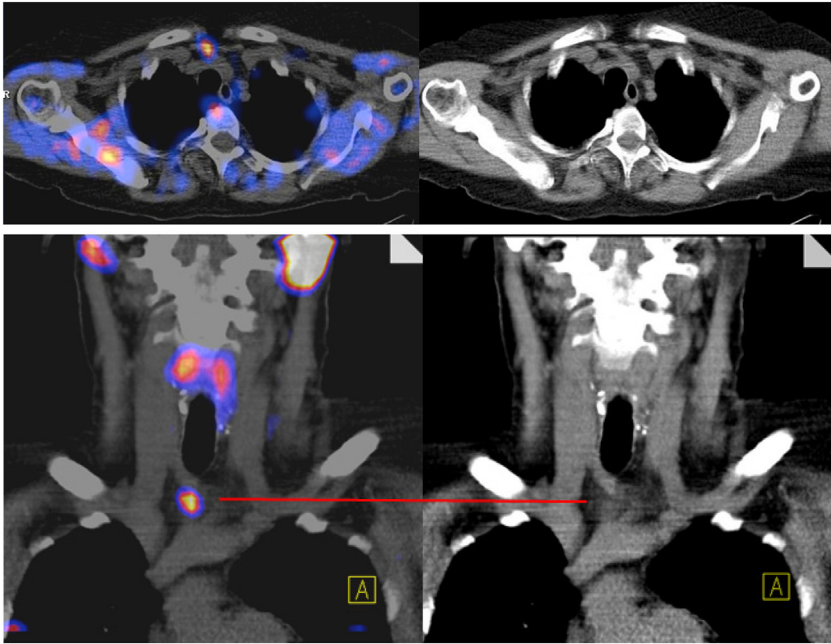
Neuroendocrine tumor of the neck in the transverse (above) and coronary plane. Normal CT on the right, SPECT on the left. The active lump is clearly visible on SPECT (red bar, gray bar in print, marks the corresponding site). *All: Courtesy: Prof. K. Scheidhauer, Klinikum rechts der Isar.*
